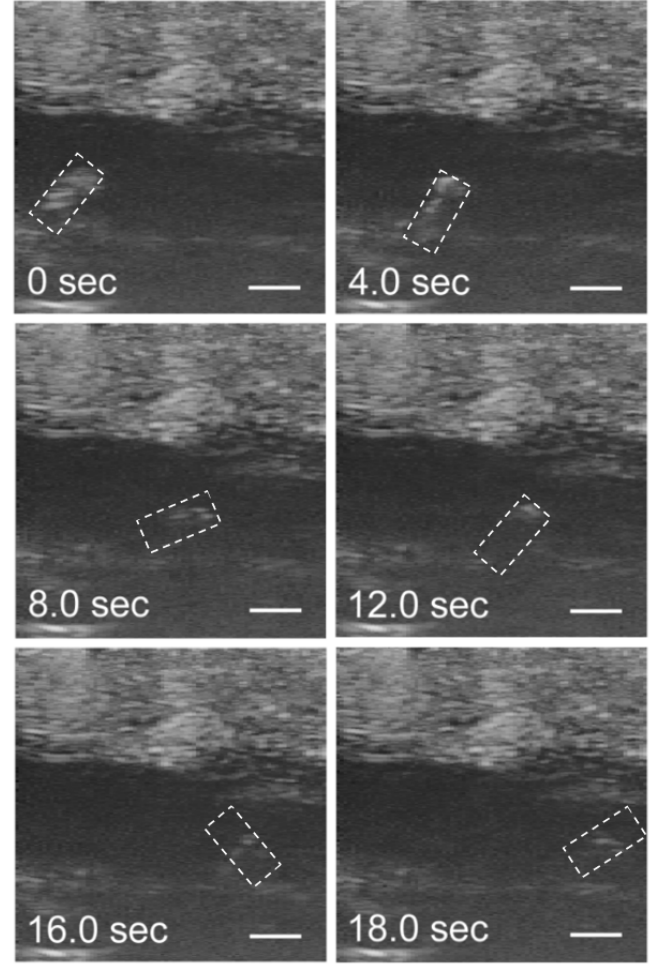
in situ* Intact Tests: Ultrasound B-mode image sequence of microrobot traveling through a 1% Tylose solution in the colon over an 18 second time period. Scale bar is 1 mm.
